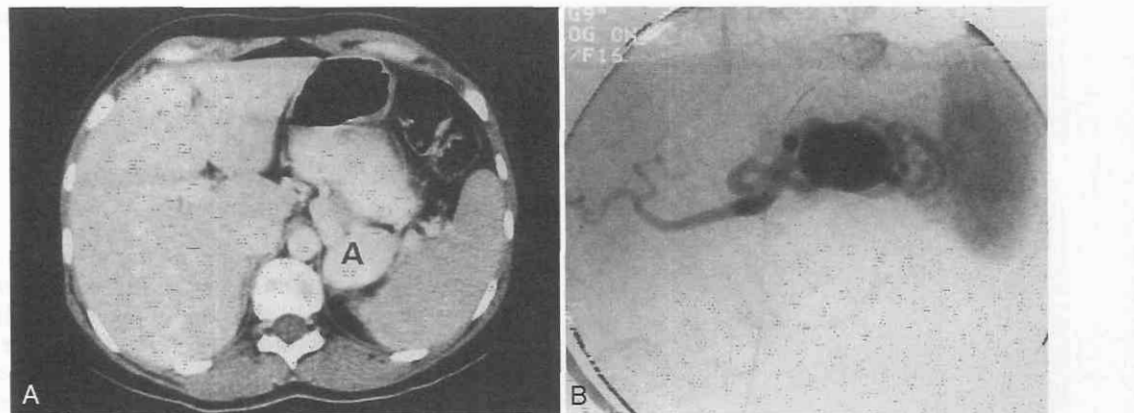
A, Although the patient was referred because of suspected tumor, the correct diagnosis of noncalcified splenic artery aneurysm was made preoperatively. CT scan with bolus dynamic contrast injection shows a high-density mass (A) in the area of the splenic pedicle, suggestive of an aneurysm. Digital subtraction angiography (DSA) was performed to document it. B, DSA shows the large aneurysm.
